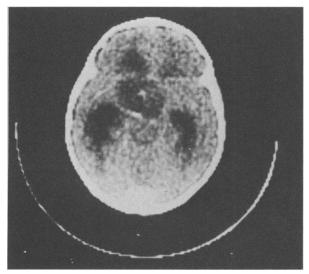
A large suprasellar cystic craniopharyngioma with central and cyst wall calcification can be seen on computed tomography scan
